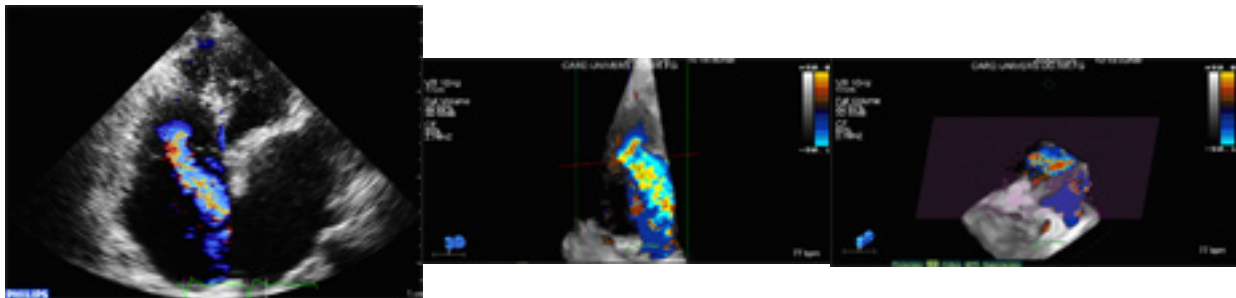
Example of image of valvular regurgitant jet In RT3DE the use of color Doppler flow mapping combined with 3D morphologic data provides clinically relevant supplementary information in patients with valvular regurgitant jets
